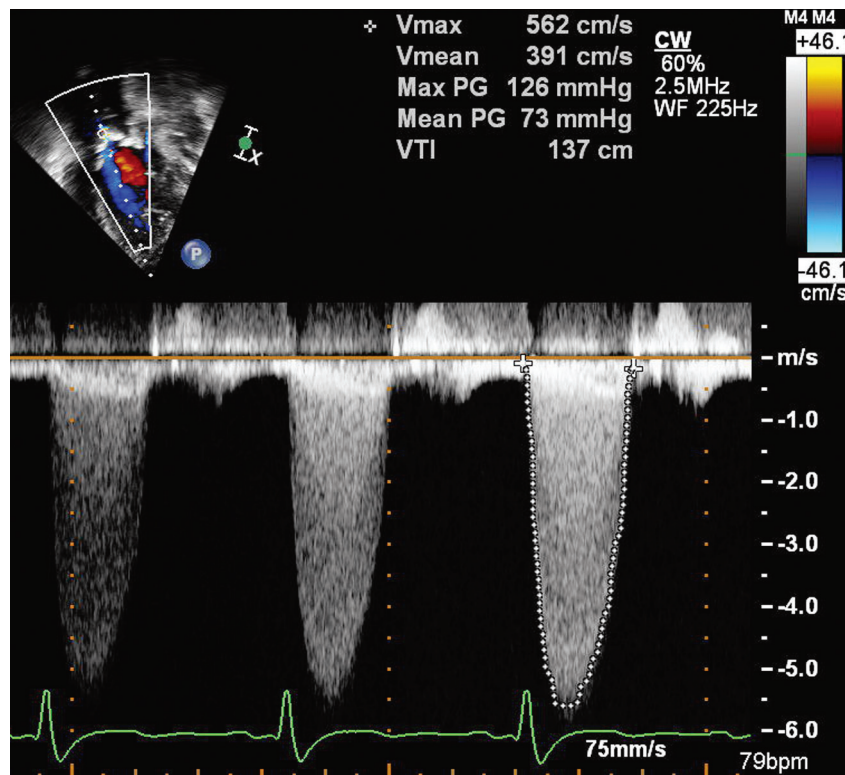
■ Doppler echocardiography. Visualization of a high-velocity jet by color Doppler aids in aligning the continuous wave Doppler cursor in a patient with severe aortic valve stenosis (maximal instantaneous and mean gradients $\approx$ 126 and 73 mm Hg, respectively).
